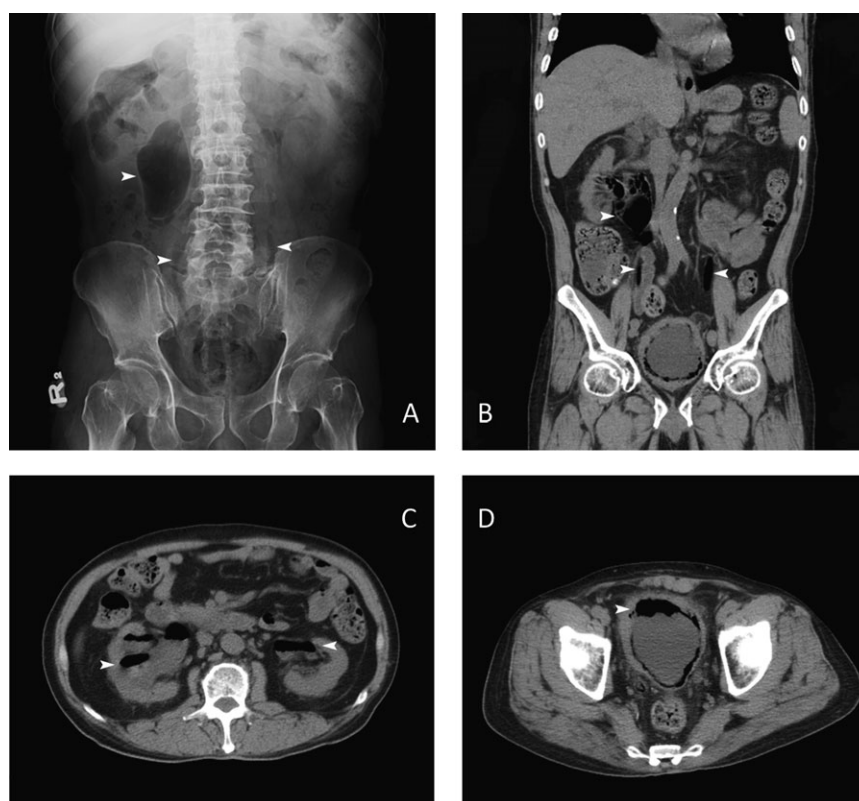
(A) Unusual gas distribution over paravertebral region (plain radiograph); (B) unusual gas distribution over right renal pelvis, bilateral ureters and urinary bladder (CT of abdomen); (C) air-fluid level over bilateral ureters and renal pelvis (CT of abdomen); (D) diffuse amorphous gas shadows on the bladder wall (CT of abdomen).
